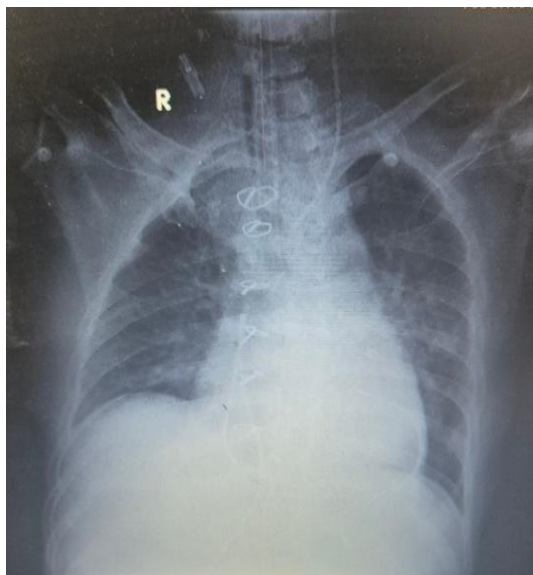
Chest X-ray AP view of the patient post pericardiocentesis and intubation: pericardial catheter in situ.
